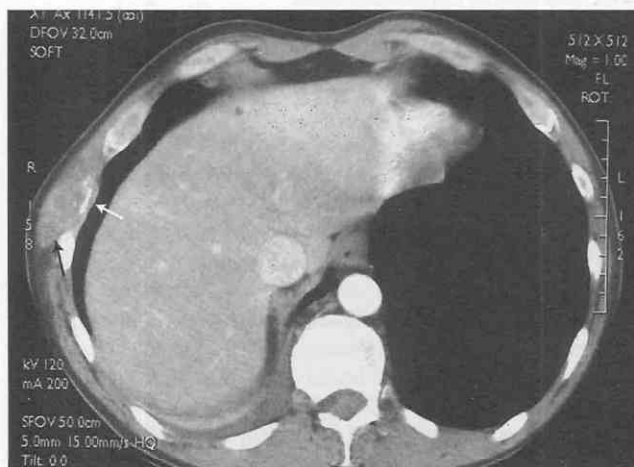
CT of right chest wall adenocarcinoma of unknown primary. Ovoid, soft tissue mass (arrows) has destroyed the right lateral rib and distorts the normal musculature.
